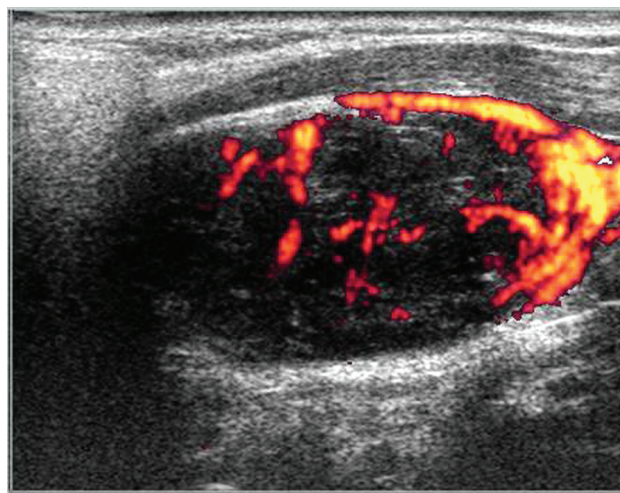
A longitudinal PD sonographic image reveals a well-circumscribed heterogeneous markedly hypoechoic solid mass in the right posterior cervical space. The mass is hypoechoic compared with the sternocleidomastoid muscle, with prominent vascularity.
